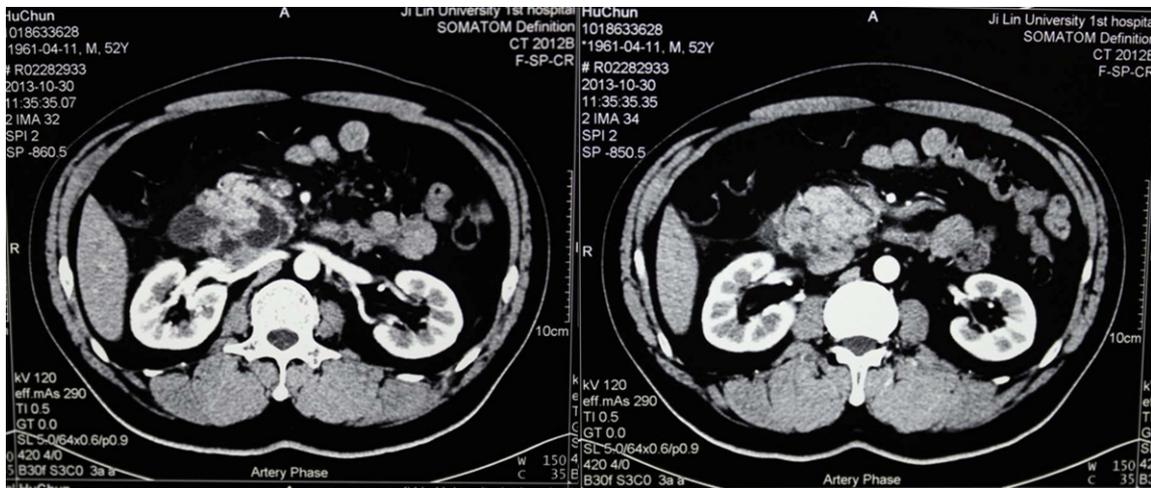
The contrast-enhanced computed tomography (CT) scan revealed the tortuous low density strips in the head of pancreas, which was considered as the dilated branch pancreatic duct.
